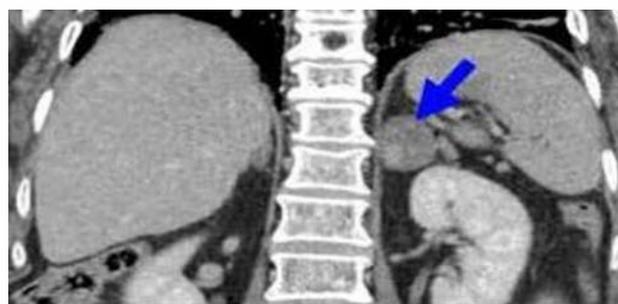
An abdominal and retroperitoneal CT shows pheochromocytoma and volume formation in the left adrenal gland.
